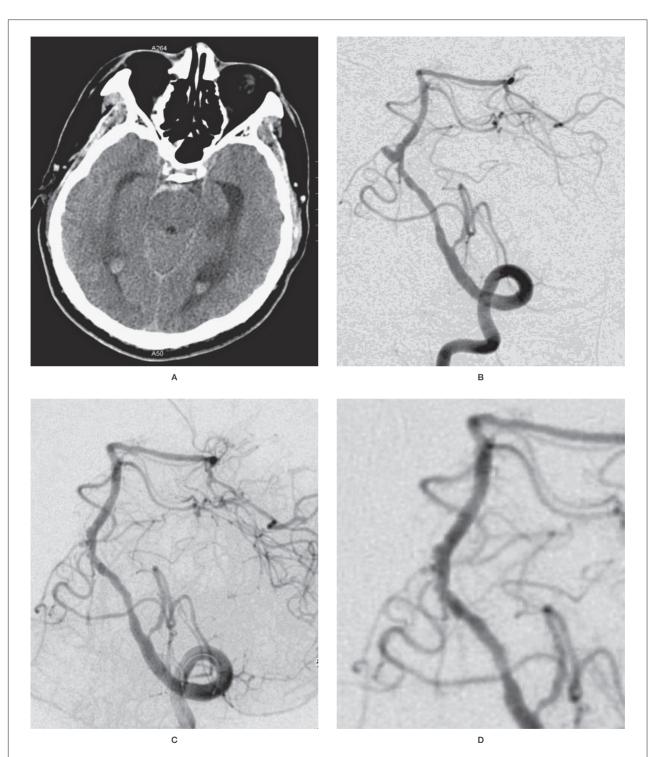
BA-AICA berry aneurysm (Case 10). A) CT showing SAH mainly in front of the ambient cistern and hematocele in the posterior horn of the lateral ventricle. B) DSA showing a side-wall berry aneurysm at the origin of the AICA. C) DSA showing aneurysm occlusion and preserved patent parent artery. D) Follow-up DSA showing no aneurysm recanalization.
